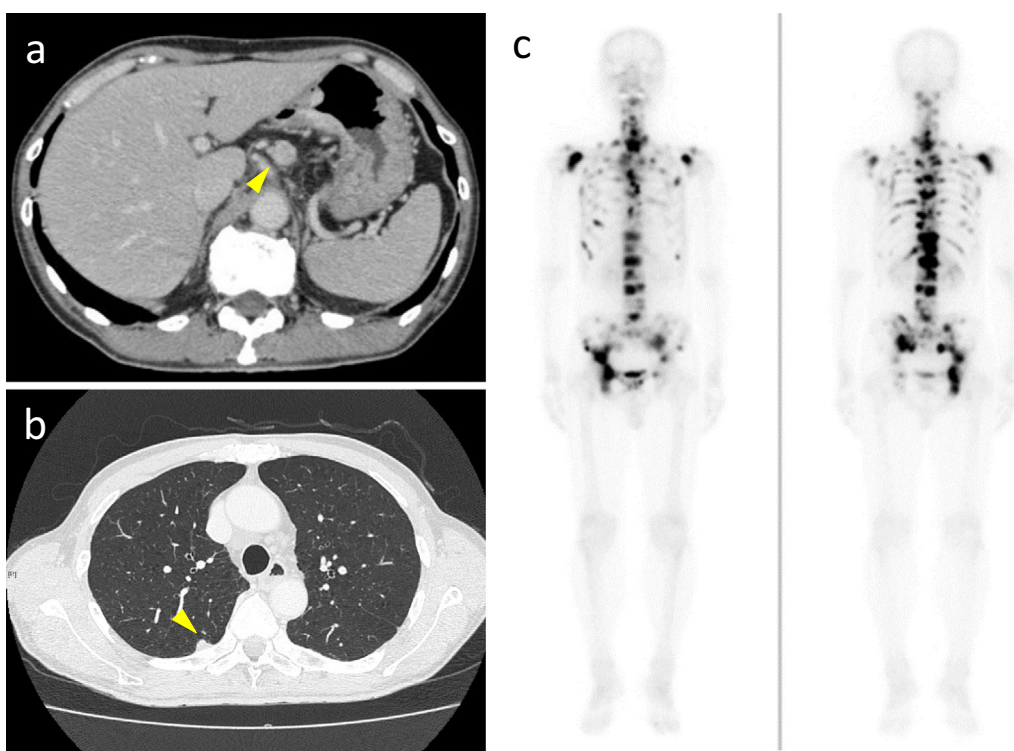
Contrast-enhanced CT at the first examination. a: Swelling of the regional lymph node. b: Metastatic lung tumor in the right lobe. c: Bone scintigraphy showing numerous whole-body bone metastases.
